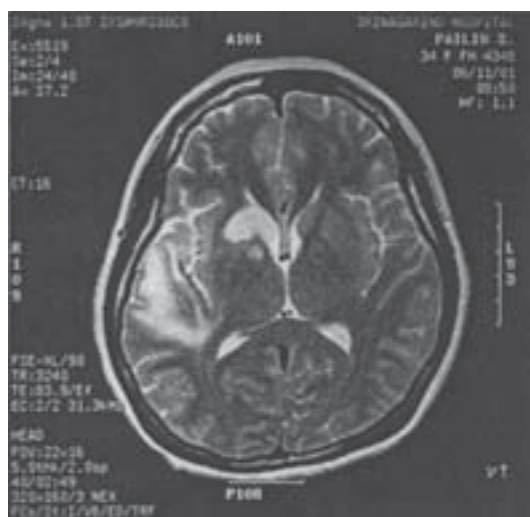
MRI of the brain revealed hyperintensity lesions at the right temporal lobe and the right basal ganglia on T2W images.
